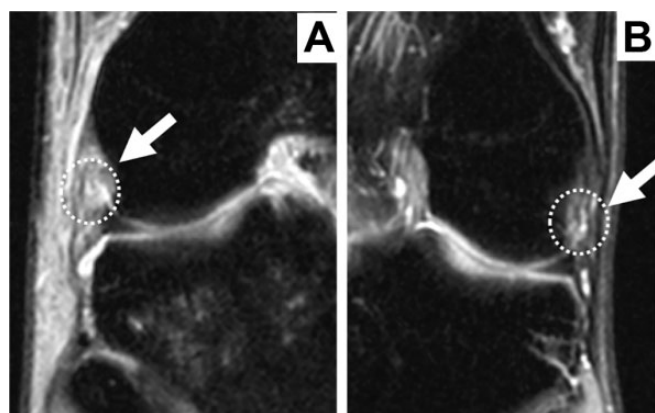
Coronal T2-weighted magnetic resonance images (MRIs) with fat saturation of the (A) injured right knee and (B) uninjured left knee of a patient. The arrows and dotted circle indicate the anterolateral ligament. MRI of the right knee demonstrated a slightly thickened anterolateral ligament with increased signal compared with the contralateral side.
